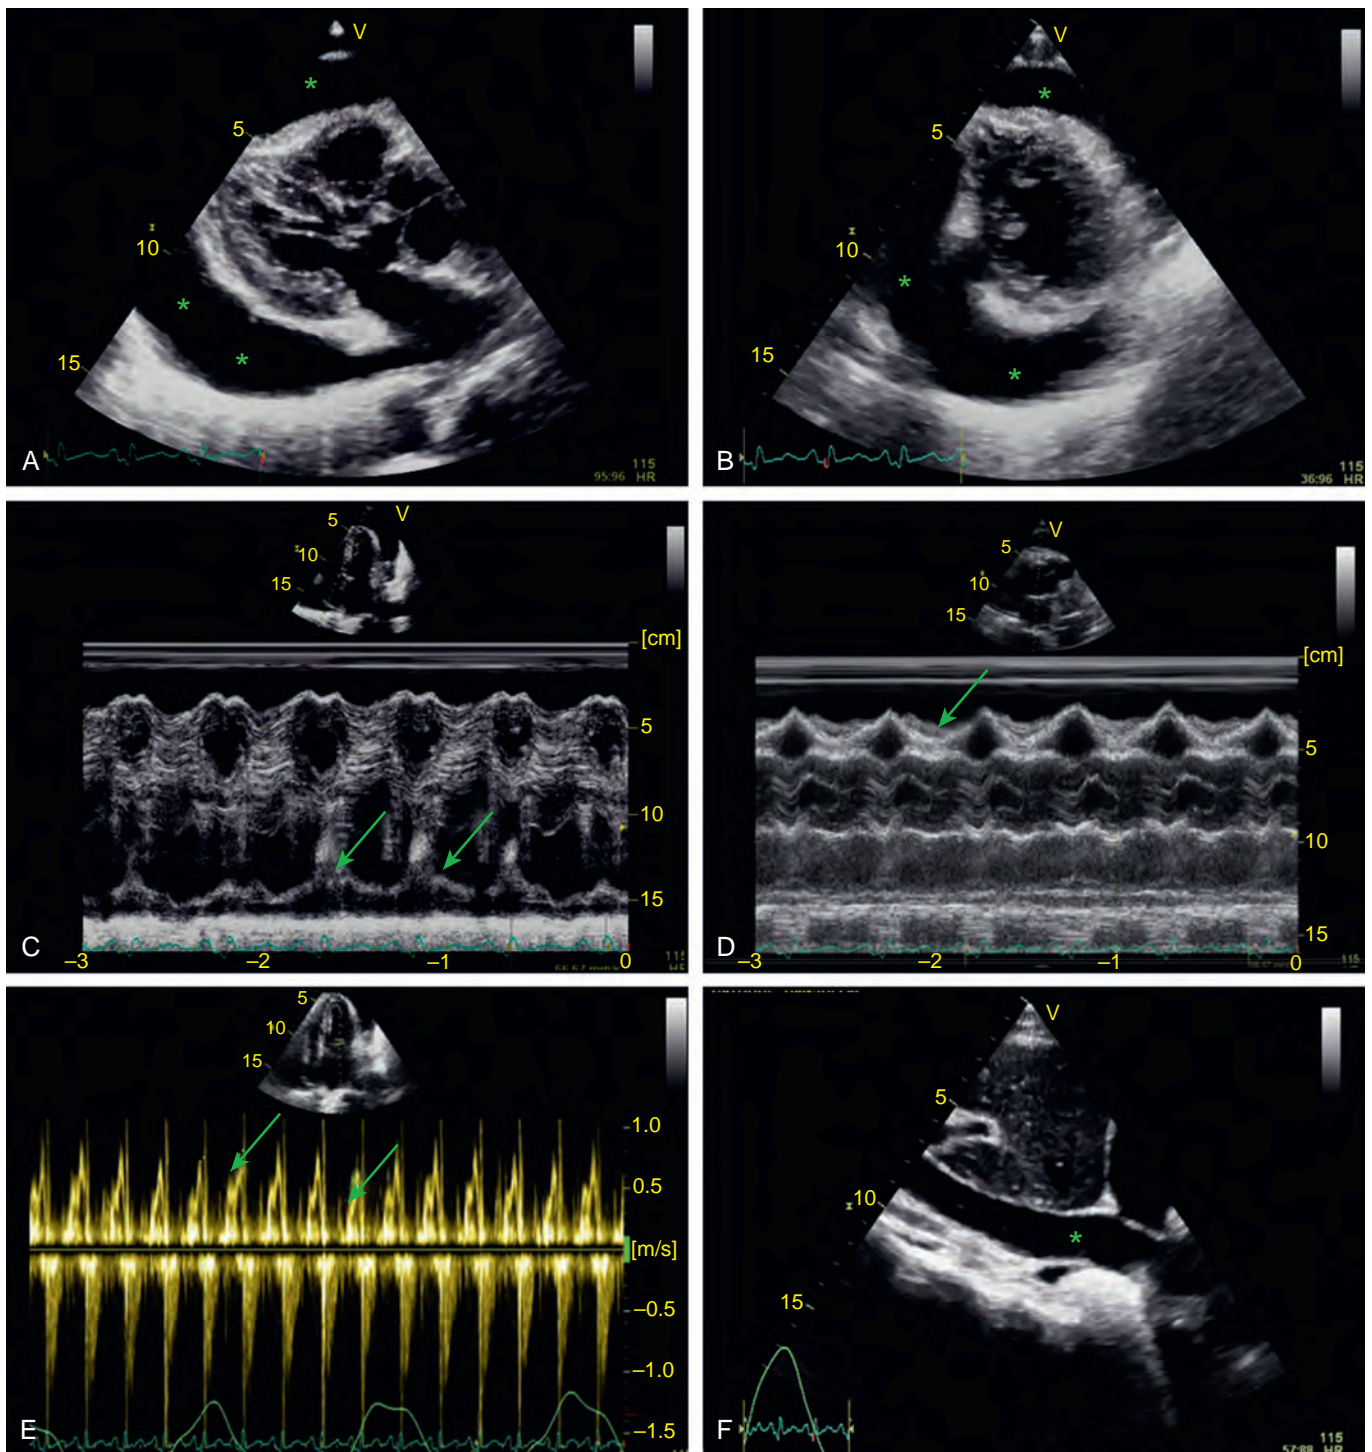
A patient with cardiac tamponade. Parasternal long-axis view (A) and short-axis view (B) show a large circumferential pericardial effusion (asterisks). C, Late diastolic right atrial collapse (arrows). D, Early diastolic right ventricular collapse (arrow). E, Significant respiratory variation in mitral inflow velocities (arrows). F, Dilated inferior vena cava (asterisk) suggestive of elevated right heart filling pressure.
